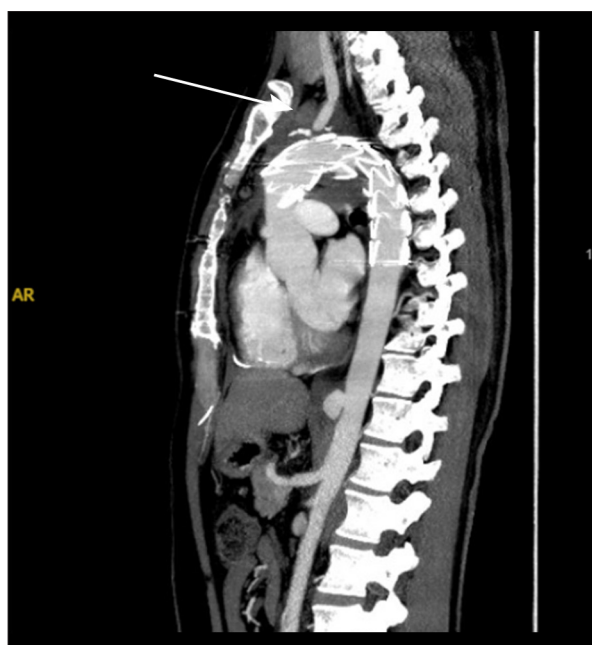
Computed tomography angiography (sagittal view) showing a superior mediastinal hematoma (arrow), fluid collection surrounding the graft, and a localized pericardial hematoma.
